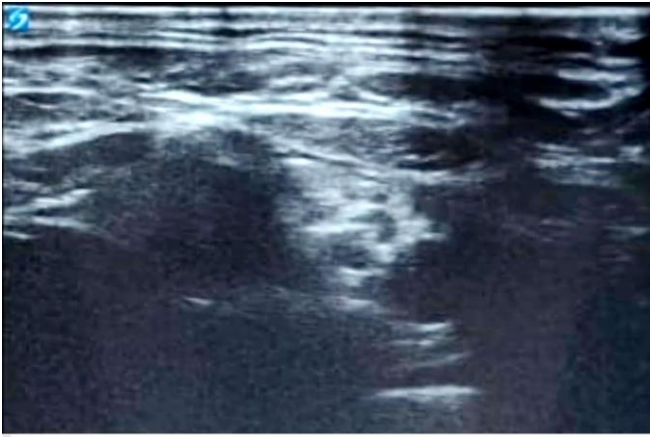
Ultrasound image of supraclavicular catheter after placement.
